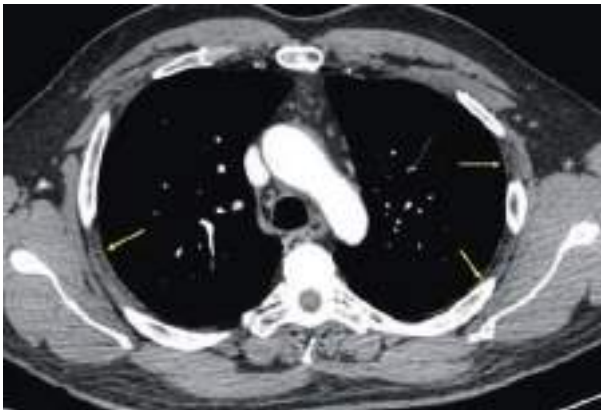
Axial contrast-enhanced CT image (mediastinal window). Intercostal band represented by a thin line corresponding to the innermost intercostal muscle (arrows).
